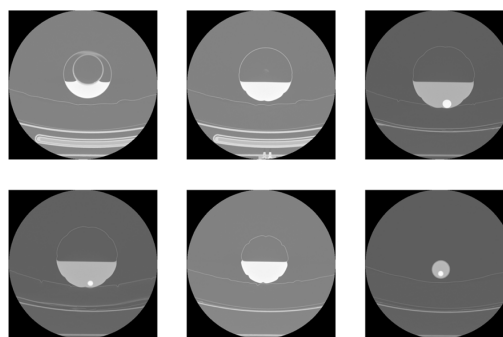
Six CT segments of "Blue large BB" in axial view.
